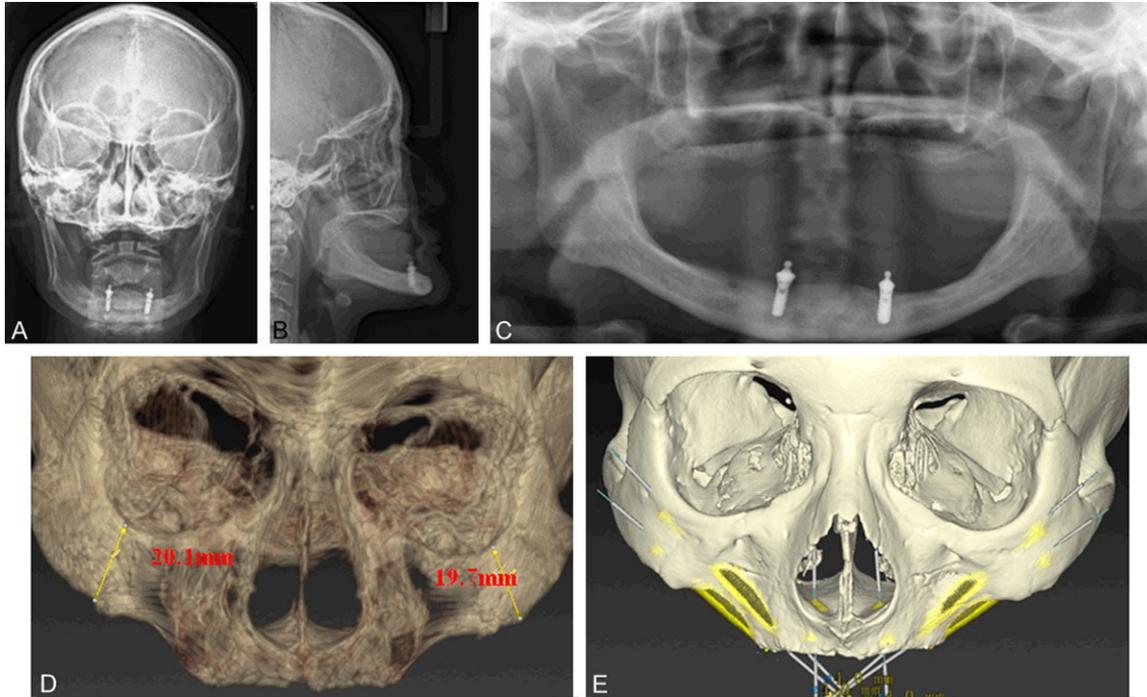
Patient I A-C: Cephalogram and orthopantomograms were taken to evaluate the resorption of maxilla, maxilla-mandible relationship and to exclude sinus disease pre-surgery; D: The minimum ZB width for ZIs anchorage were 19.7 mm and 20.1 mm respectively in 3D reconstruction with software; E: Two ZIs were planned to place bilaterally in 3D reconstruction.
